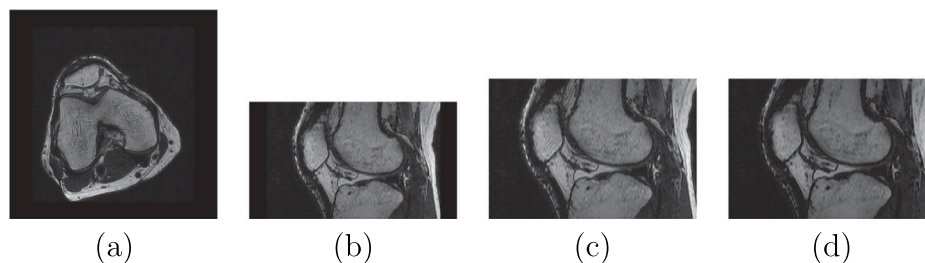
Pre-processing of an axial MR image of size $512 \times 512 \times 286$: (a) original view; (b) sagittal view; (c) selected ROI; (d) bone contours enhancement.
